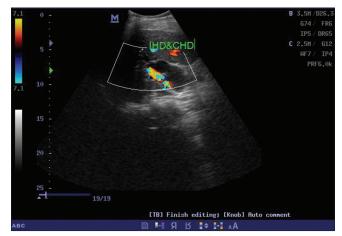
Doppler ultrasound scan picture showing the fusiform dilatation of the common bile and the hepatic artery
